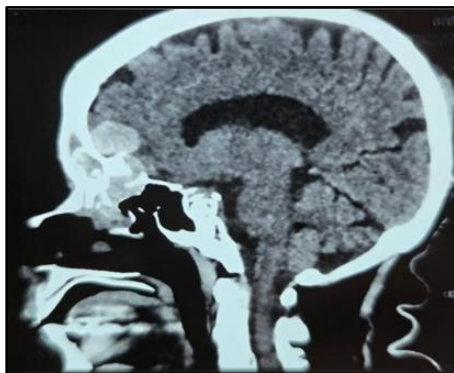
Pre-operative CT – sagittal sectional view of paranasal sinuses
